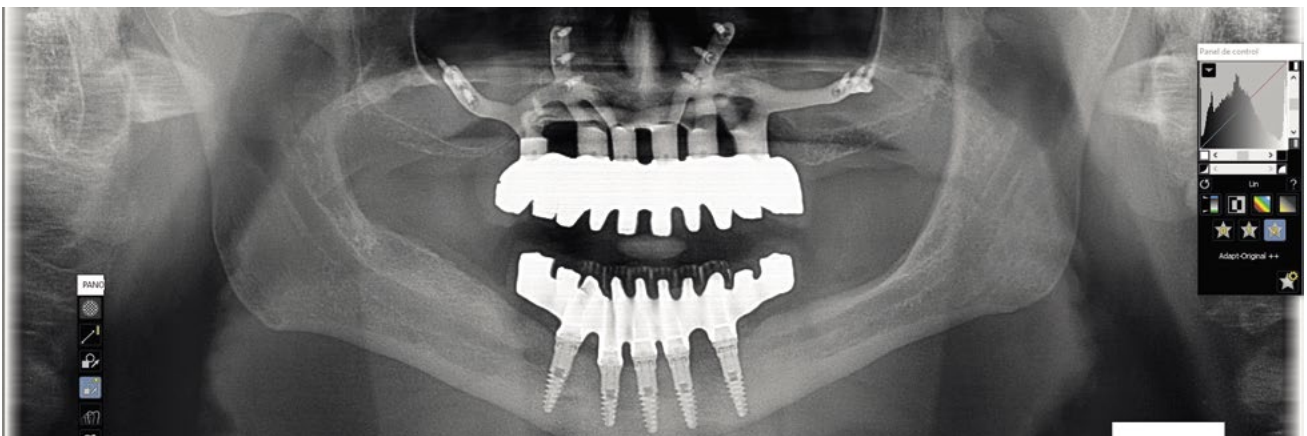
Orthopantomography with implant-supported final rehabilitation.
